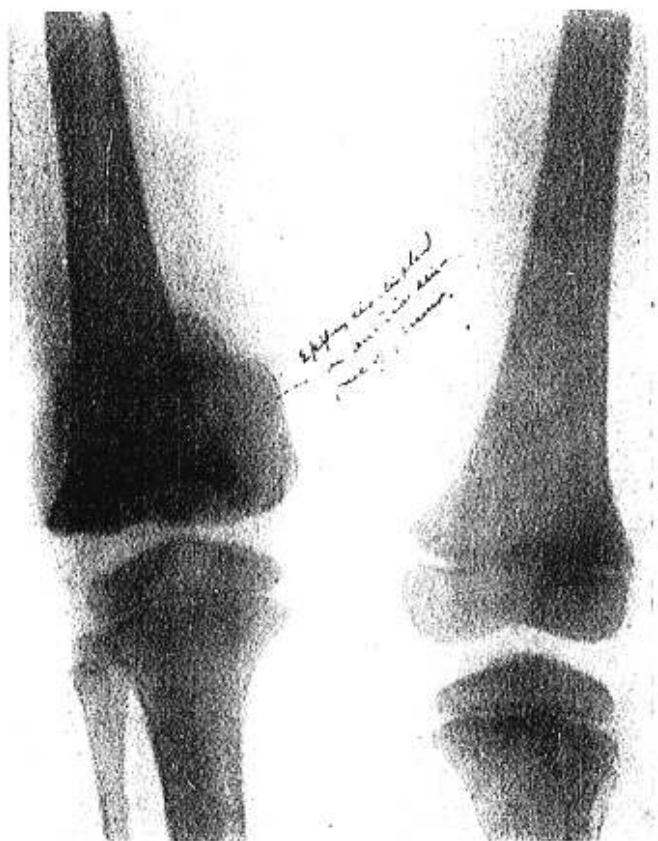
Radiograph of normal and injured extremities taken July 10, 1904, two months after injury. Anteroposterior view.
